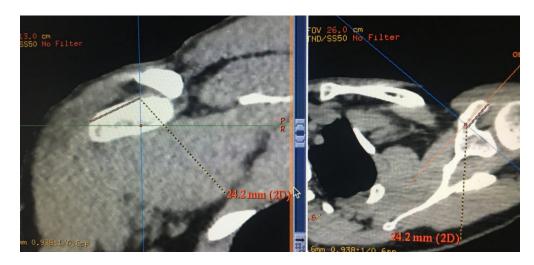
Computed tomography-guided measurement for the length of the coracoid.
